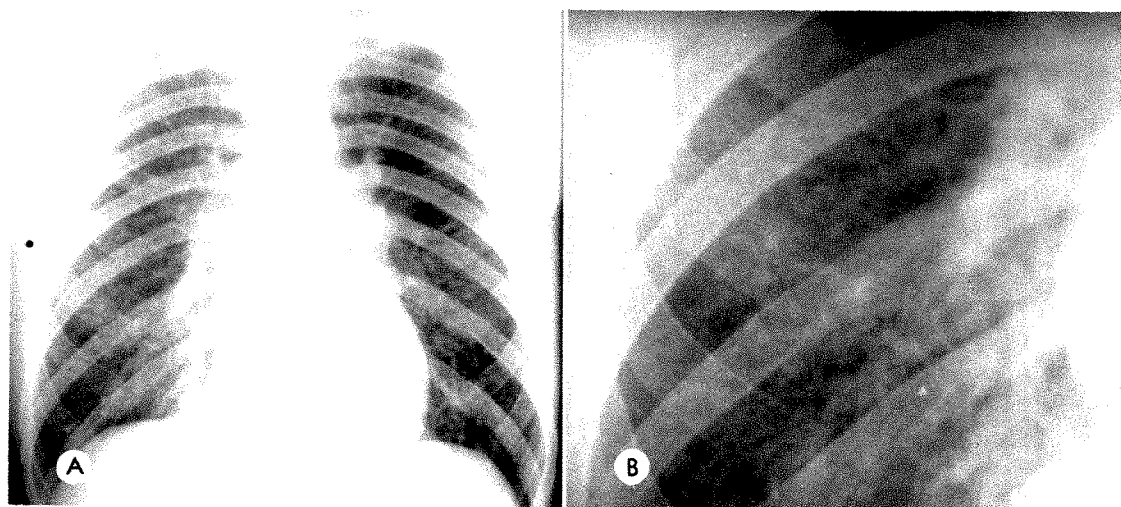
(*A*) Posteroanterior roentgenogram of the chest shows a widely disseminated, finely nodular infiltration throughout both lung fields. Several small areas of confluence of the nodules are present but no frank consolidation. (*B*) A slightly magnified view of the right middle lung field demonstrates the finely reticulated background as well as the nodular infiltration.
